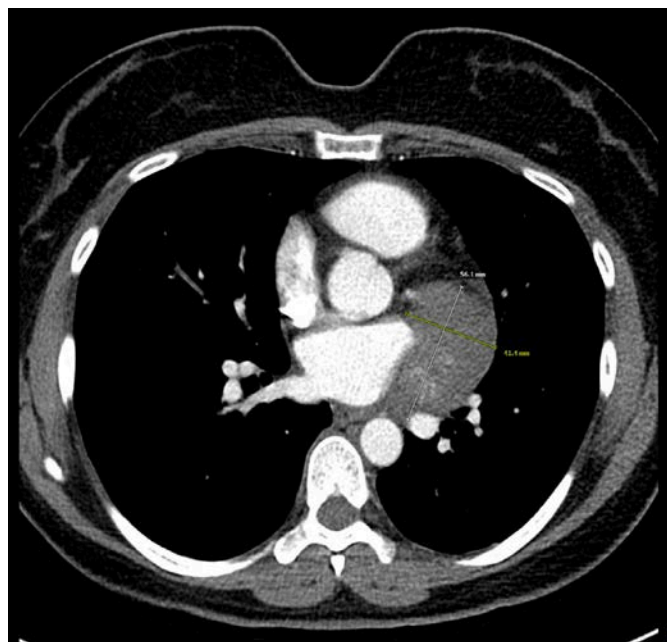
Chest CTA revealing the large pericardial mass.
